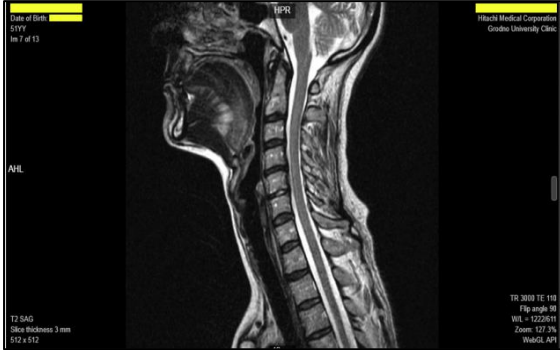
MRI of cervical spine showing degenerative changes.
